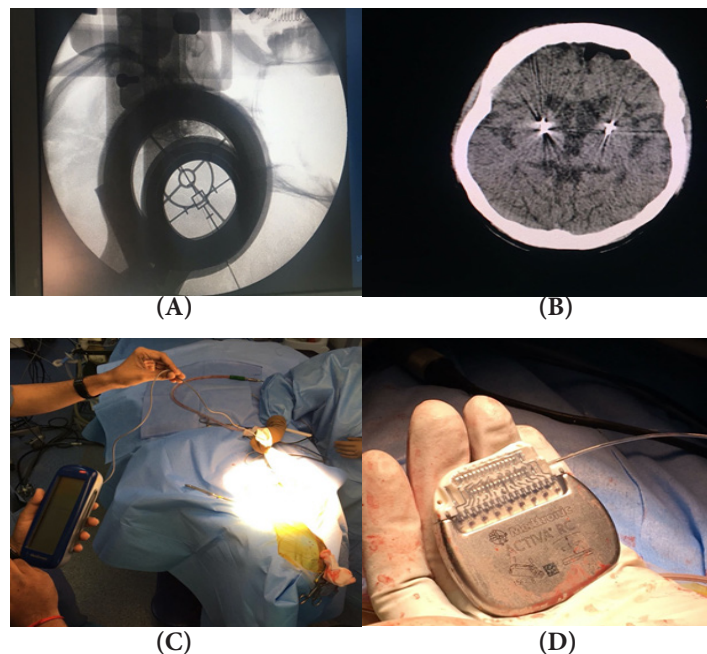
POSITIONING: The electrode positioning is confirmed on intraoperative X-ray in [A], and the final position of the electrodes are confirmed in a post procedure CT in [B] The wiring is tunneled through to the chest in [C] and the Implantable pulse Generator (IPG seen in [D])
